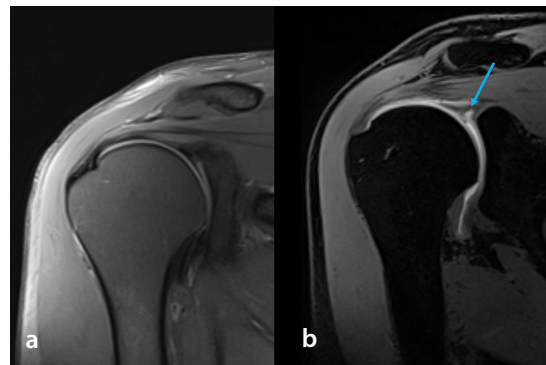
Coronal oblique plane PD MR imaging (a) of the right glenohumeral joint shows no pathology in the superior labrum; however, T1-weighted VIBE MR arthrography (b) reveals a type 2 SLAP lesion (blue arrow). PD, proton density; MR, magnetic resonance; VIBE, volumetric interpolated breath-hold examination.
